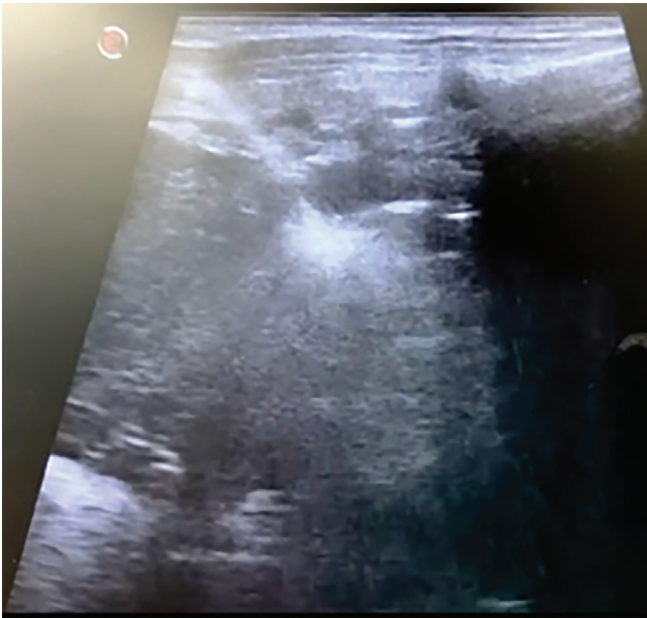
Needle tracking inside lung mass while performing ultrasound guided biopsy
